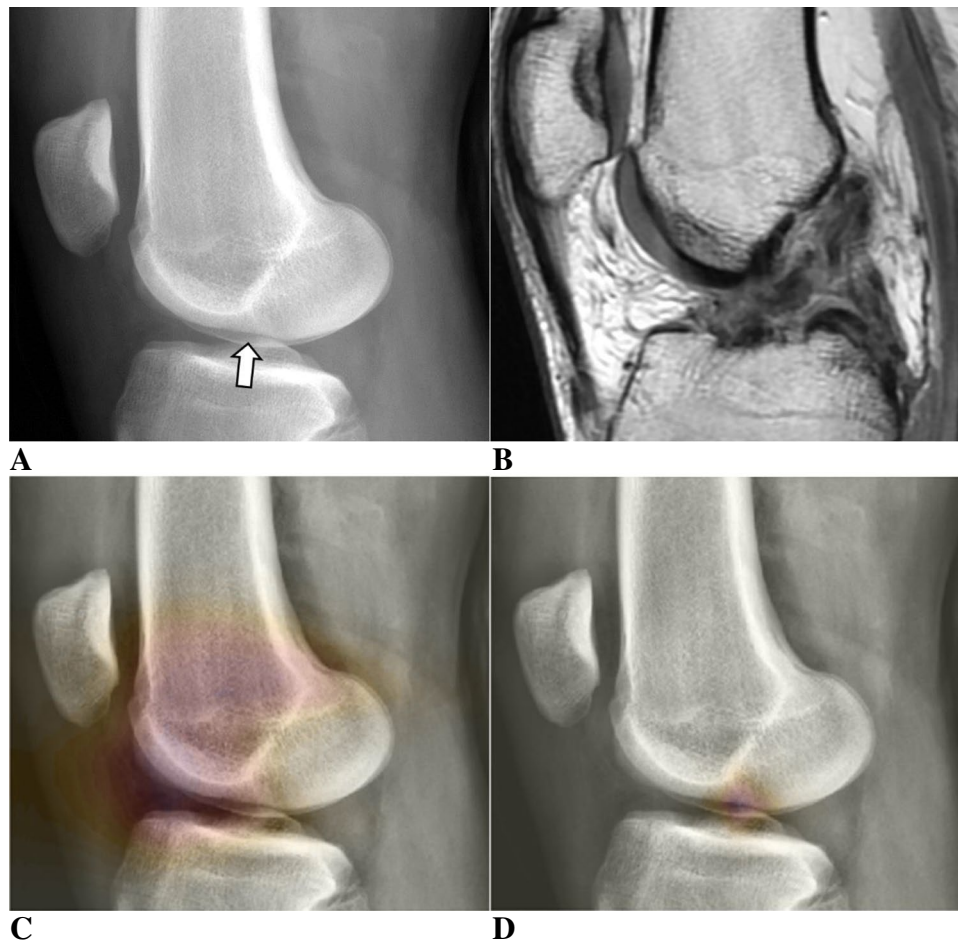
Images in a 24-year-old man with anterior cruciate ligament (ACL) tear in which the ensemble ACL tear model made correct predictions but all human reviewers made incorrect predictions. A Cropped lateral knee radiograph shows a long lateral femoral notch (arrow). Joint effusion in supra-patellar recess is within a physiologic amount. Reviewers labeled this image as grade 3 (indeterminate), 3, and 2 (probably absent), respectively. The probability score from the ensemble ACL tear model for the presence of ACL tear was 0.91. B Proton density weighted sagittal MRI shows complete tear of ACL.
